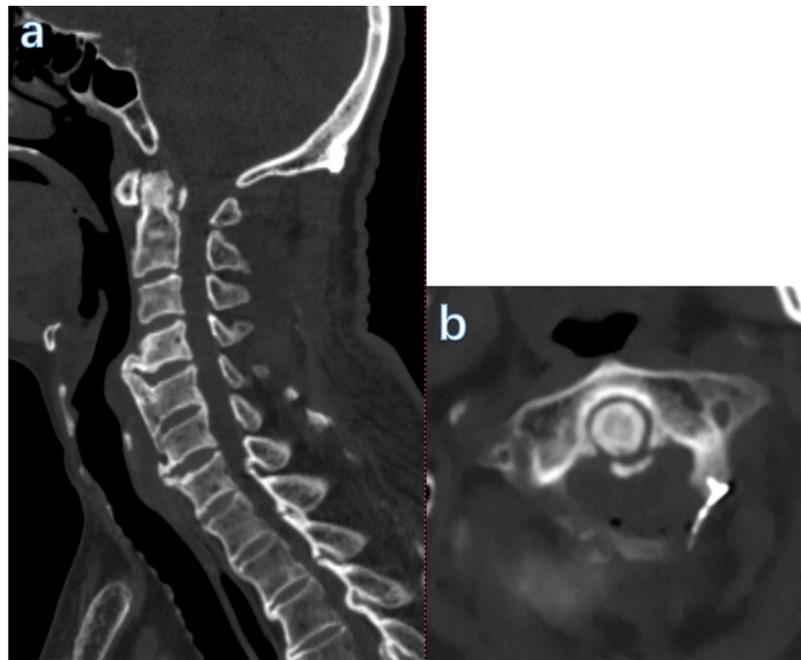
a, b. Postoperative sagittal and axial CT scan showing the diameter of the spinal canal is significantly increased compared with preoperative.
